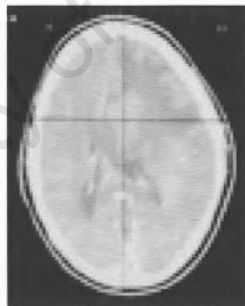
Axial CT scan demonstrating the target used for the third stereotactic biopsy.
